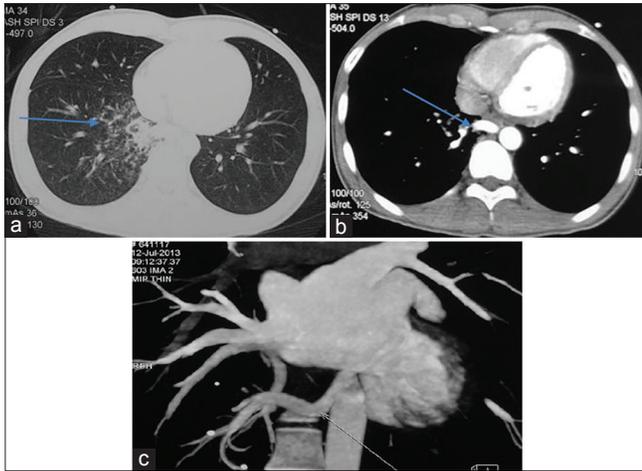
A 34-year-old male with recurrent infection in the right lower lung. Focal ground-glass density and patchy opacity at the right lower lung are evident on axial computed tomography (a) (fine arrow). An aberrant artery arising from the descending thoracic aorta, supplying the medial right lower lobe (b) (fine arrow). An aberrant artery arising from the descending thoracic aorta, running directly into the medial right lower lobe on computed tomography angiography and three-dimensional reconstruction of thoracic aorta (c) (fine arrow)
